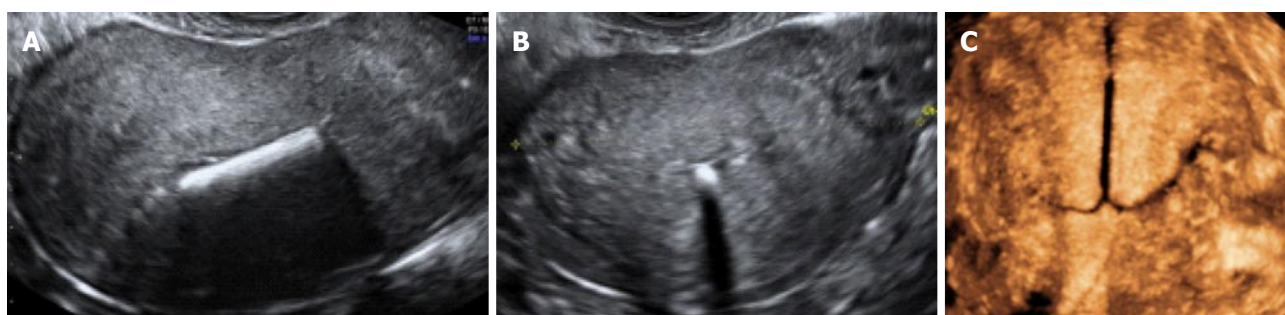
Malposition of an intrauterine device. Sagittal (A) and transverse (B) 2D ultrasound image showing the shaft within the endometrial cavity; C: Coronal 3D ultrasound image showing the IUD lying inverted with both arms embedded within the myometrium. 3D: Three-dimensional; 2D: Two-dimensional; IUD: Intrauterine device.
